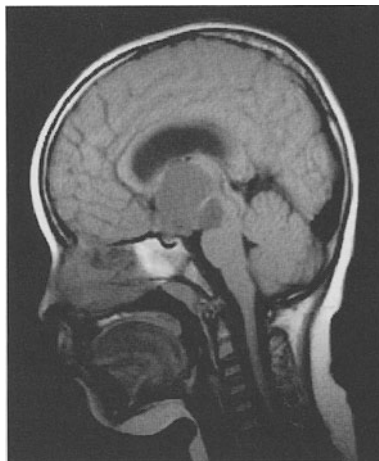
T1-weighted MR (TR 600, TE 30) demonstrating a large suprasellar cystic mass. (Image from a 0.35-T Fonar MR system)
